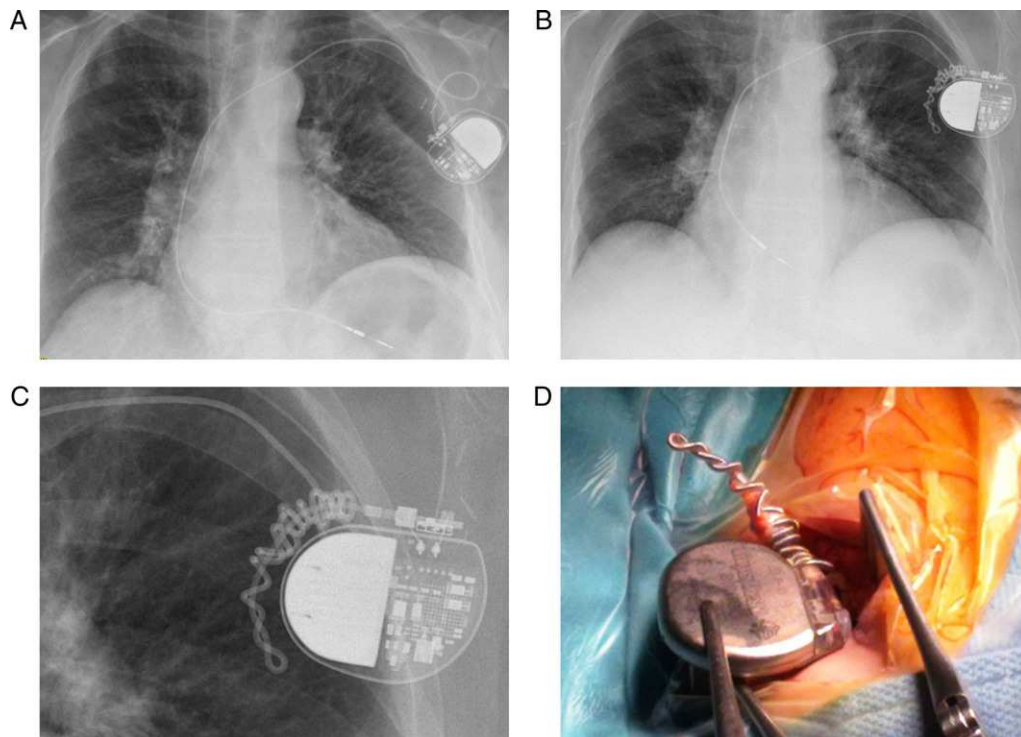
Example of twiddler syndrome in a 68-year-old patient who presented macro-dislodgement of the ventricular lead of a pacemaker implanted 2 months previously for atrial fibrillation with significant pauses. A, posteroanterior chest radiograph showing a normal lead position. B, posteroanterior chest radiograph showing lead macro-dislodgement and winding of the proximal portion over the long axis, due to generator rotation over the horizontal axis. C, detailed view of the proximal portion and generator in the radiograph. D, detailed view of the surgical revision of the system.
